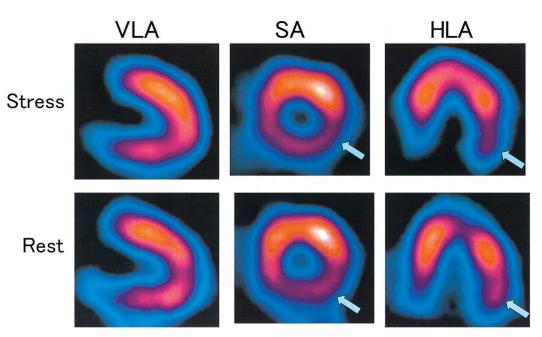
Dipyridamole stress myocardial ²⁰¹Tl single photon emission computed tomography. In the stress images (Upper), there is only slight hypoperfusion in the inferolateral segment (arrows). In the rest images, there is re-distribution of ²⁰¹Tl in the segment. VLA, vertical long-axis view; SA, short-axis view; HLA, horizontal long-axis view.
